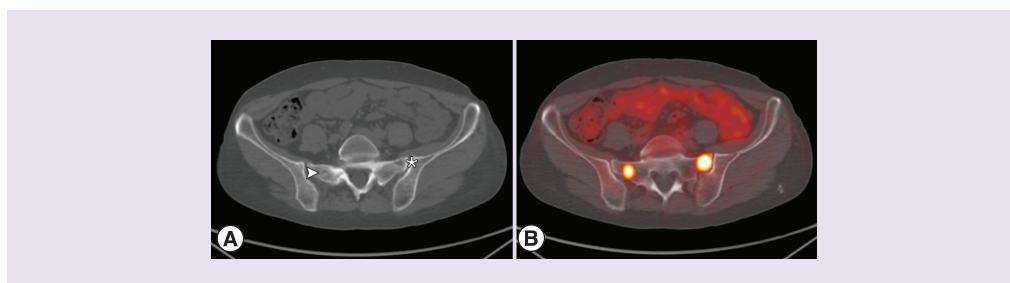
New lesion in right sacrum appeared after 16 months of therapy with lenvatinib. (A) CT and (B) PET scan of the new metastasis appeared in right sacrum (arrow) at december 2017. The lesion in left sacrum (star) was present before lenvatinib start.
